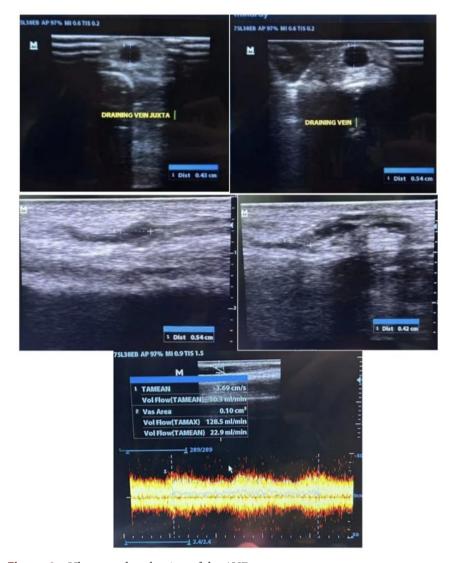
Ultrasound evaluation of the AVF
